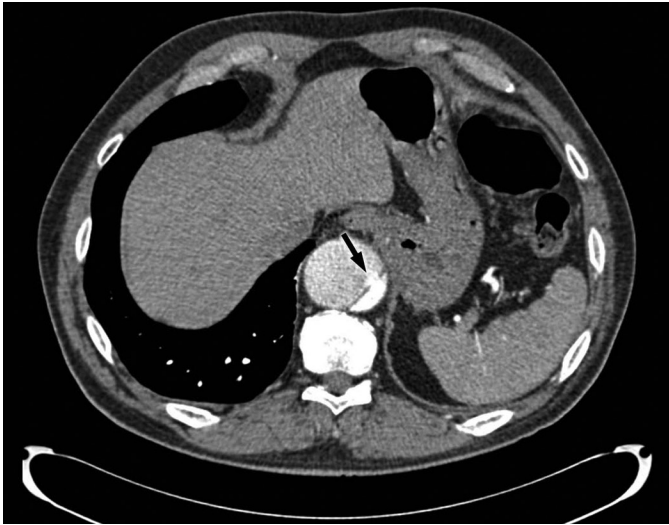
Contrast-enhanced CT scan of an aortic dissection demonstrating a fenestration in the intimal flap (arrow) with contrast material flowing from the small, densely opacified true lumen into the less opacified and larger false lumen of the aorta.
